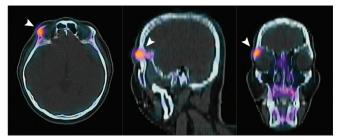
Technetium-99m methylene diphosphonate bone single photon emission computed tomography/computed tomography of the skull in axial, sagittal and coronal views. Images demonstrate focal tracer activity corresponding to the right fronto-zygomatic suture
